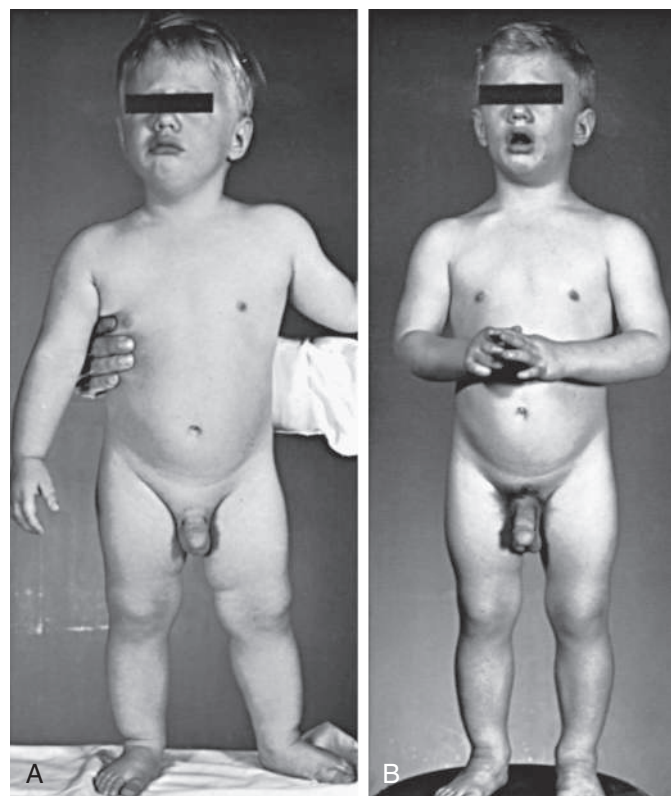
Natural course of untreated precocious puberty with central nervous system lesion. Photographs at 1½ (A) and 2½ (B) yr of age. Accelerated growth, muscular development, osseous maturation, and testicular development were consistent with the degree of secondary sexual maturation. In early infancy, the patient began having frequent spells of rapid, purposeless motion; later in life, he had episodes of uncontrollable laughing with ocular movements. At 7 yr, he exhibited emotional lability, aggressive behavior, and destructive tendencies. Although a hypothalamic hamartoma had been suspected, it was not established until CT scanning became available when the patient was 23 yr of age. Epiphyses fused at 9 yr of age; final height was 142 cm (56 in). At 24 yr of age, he developed an embryonal cell carcinoma of the retroperitoneum.
